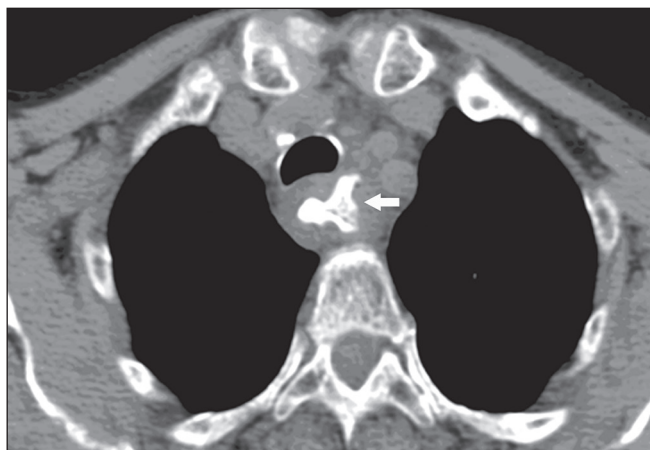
A 45-year-old woman who accidentally ingested a large lamb bone fragment. Axial CT image of the chest (mediastinal window) showing the impacted bone fragment (arrow) lodged in the dilated thoracic esophagus.
